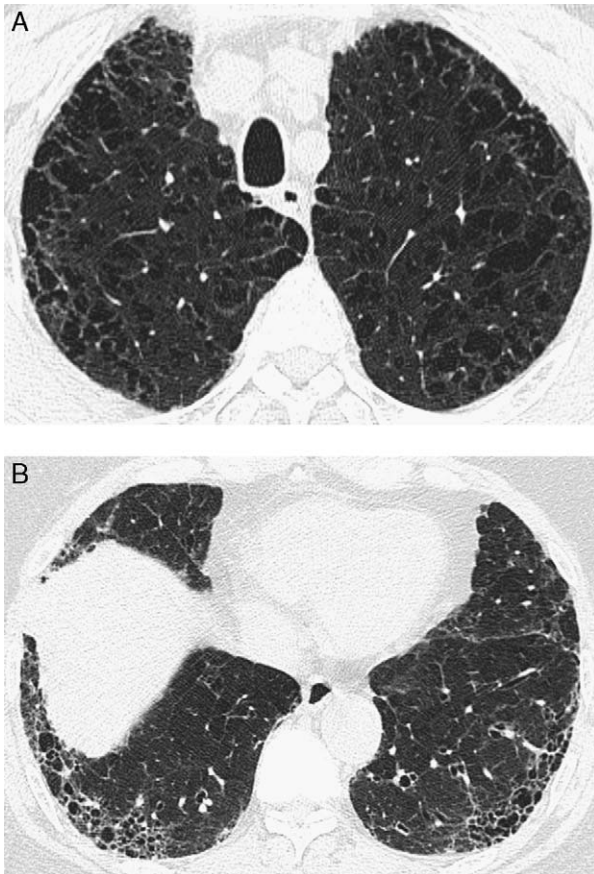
Emphysema and idiopathic pulmonary fibrosis in a 70-year-old man. A, HRCT image at the level of the upper lobes shows extensive centrilobular emphysema. B, HRCT image at the level of the dome of the right hemidiaphragm shows mild emphysema and peripheral reticulation and honeycombing.
